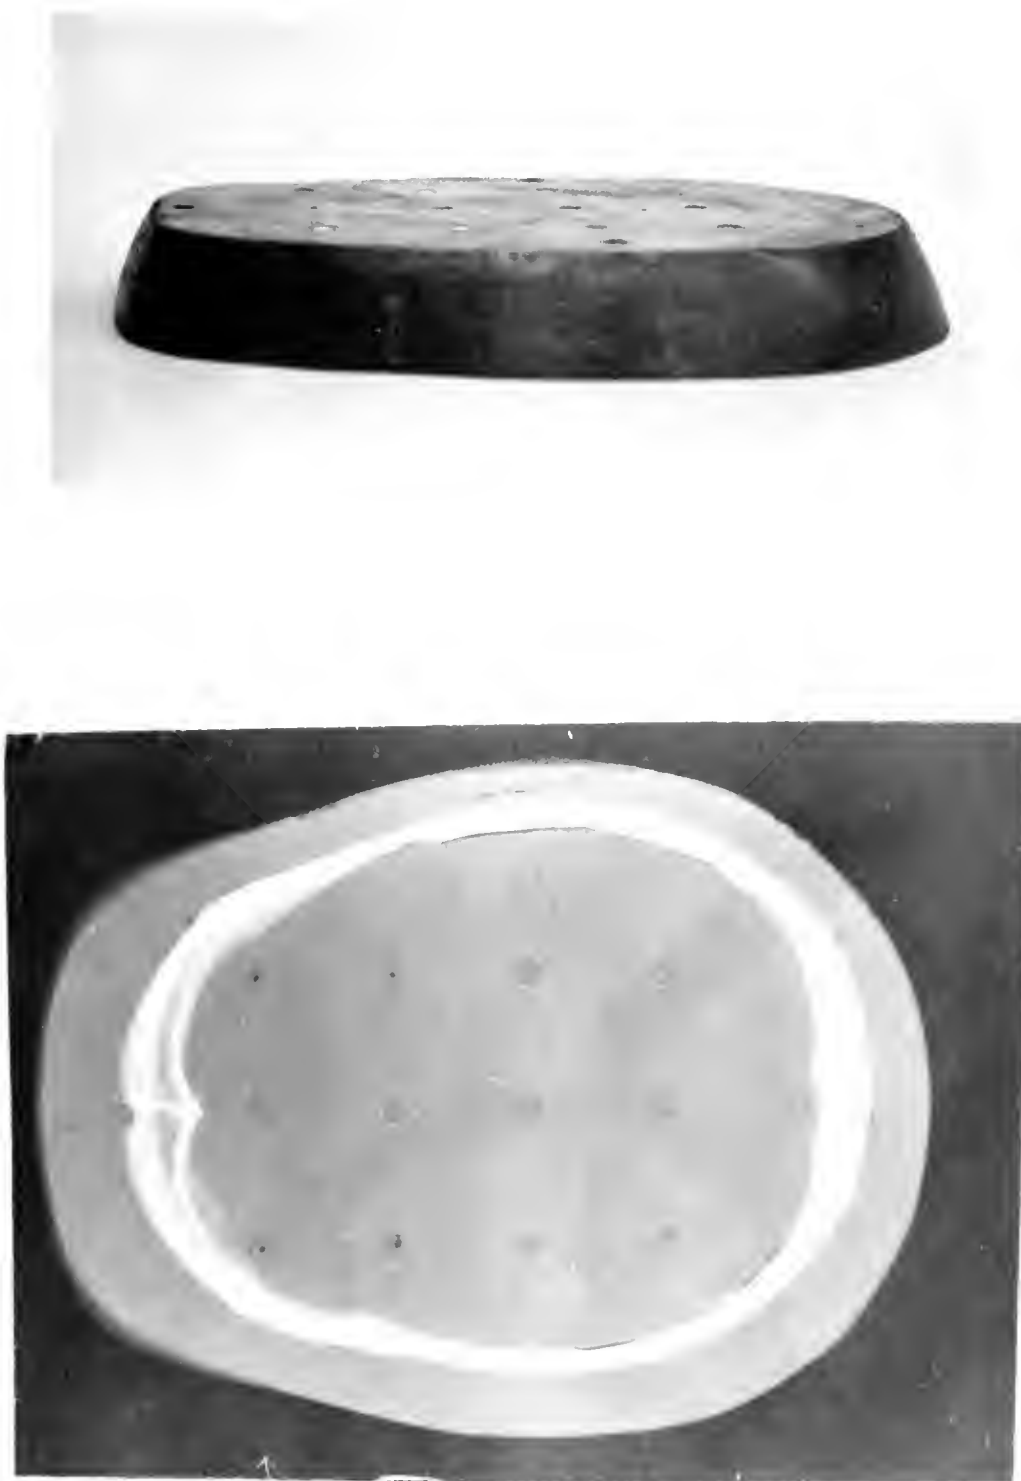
Side View and X-ray of Scanned Rando Section.
